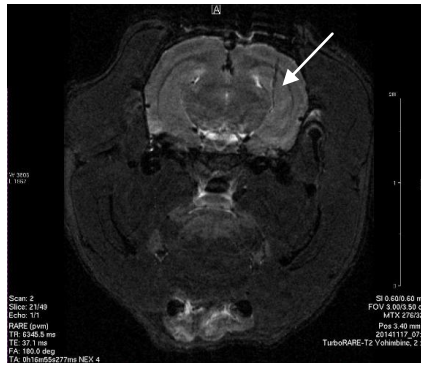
Post-mortem MRI scans: the original electrode tract (white arrow) is preserved.
